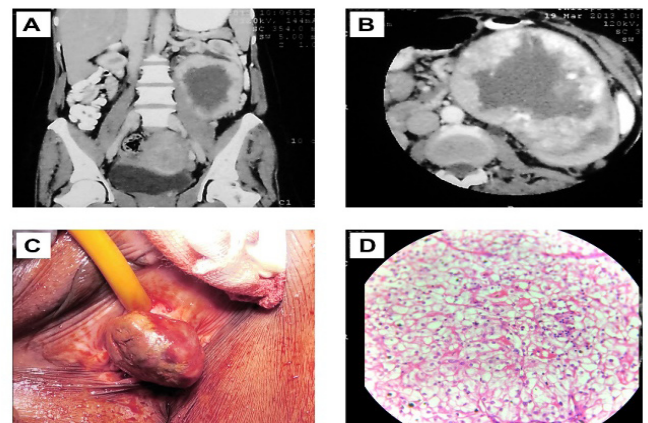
Panel A& B: CT images of large left RCC which was removed by radical nephrectomy
